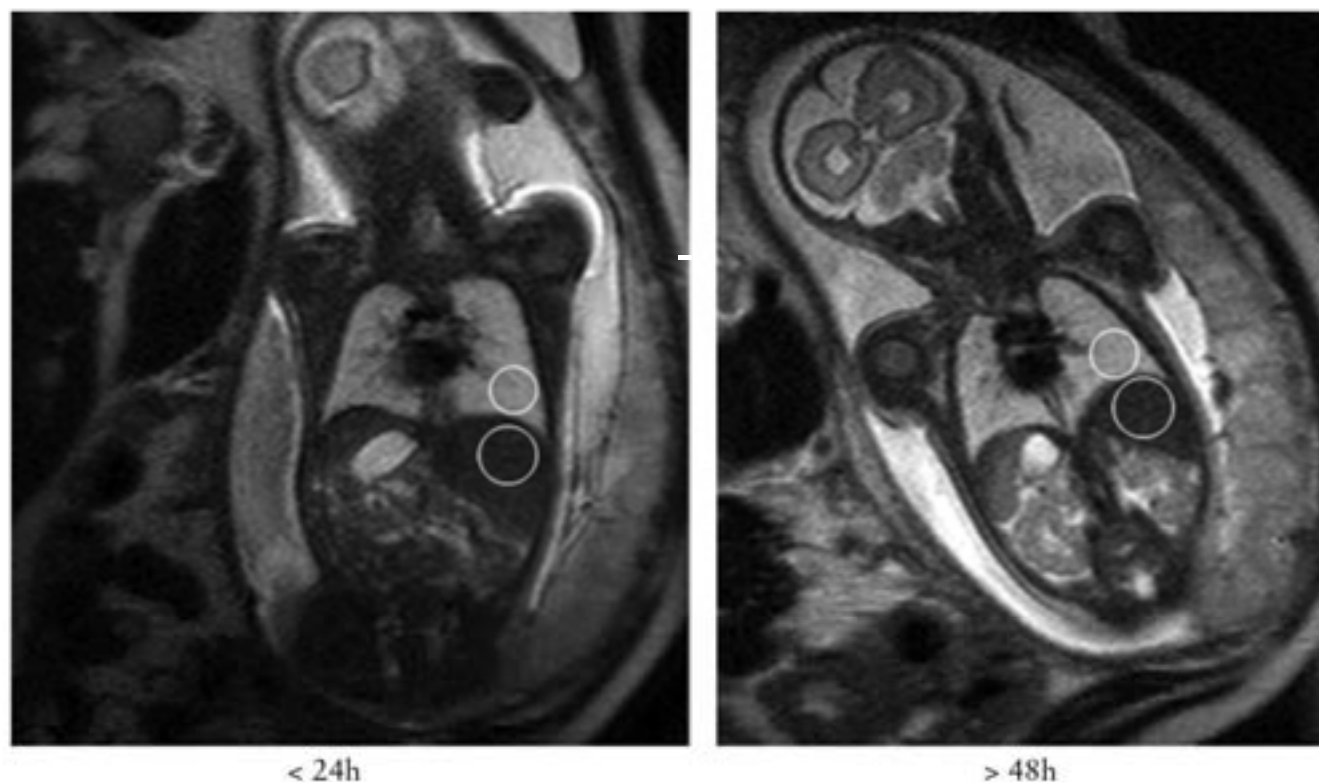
T2-weighted magnetic resonance images of a fetus at 27 gestational weeks. Time point '< 24 h' was within 24 h after the first dose of betamethasone. Time point '> 48 h' was after the second dose of betamethasone, more than 48 h after the first dose. For the fetus shown, the time spans for '< 24 h' and '> 48 h' were 2 h 38 min and 77 h 23 min, respectively. The regions of interest for signal intensity measurement in the lung and the liver are depicted (white circles).
